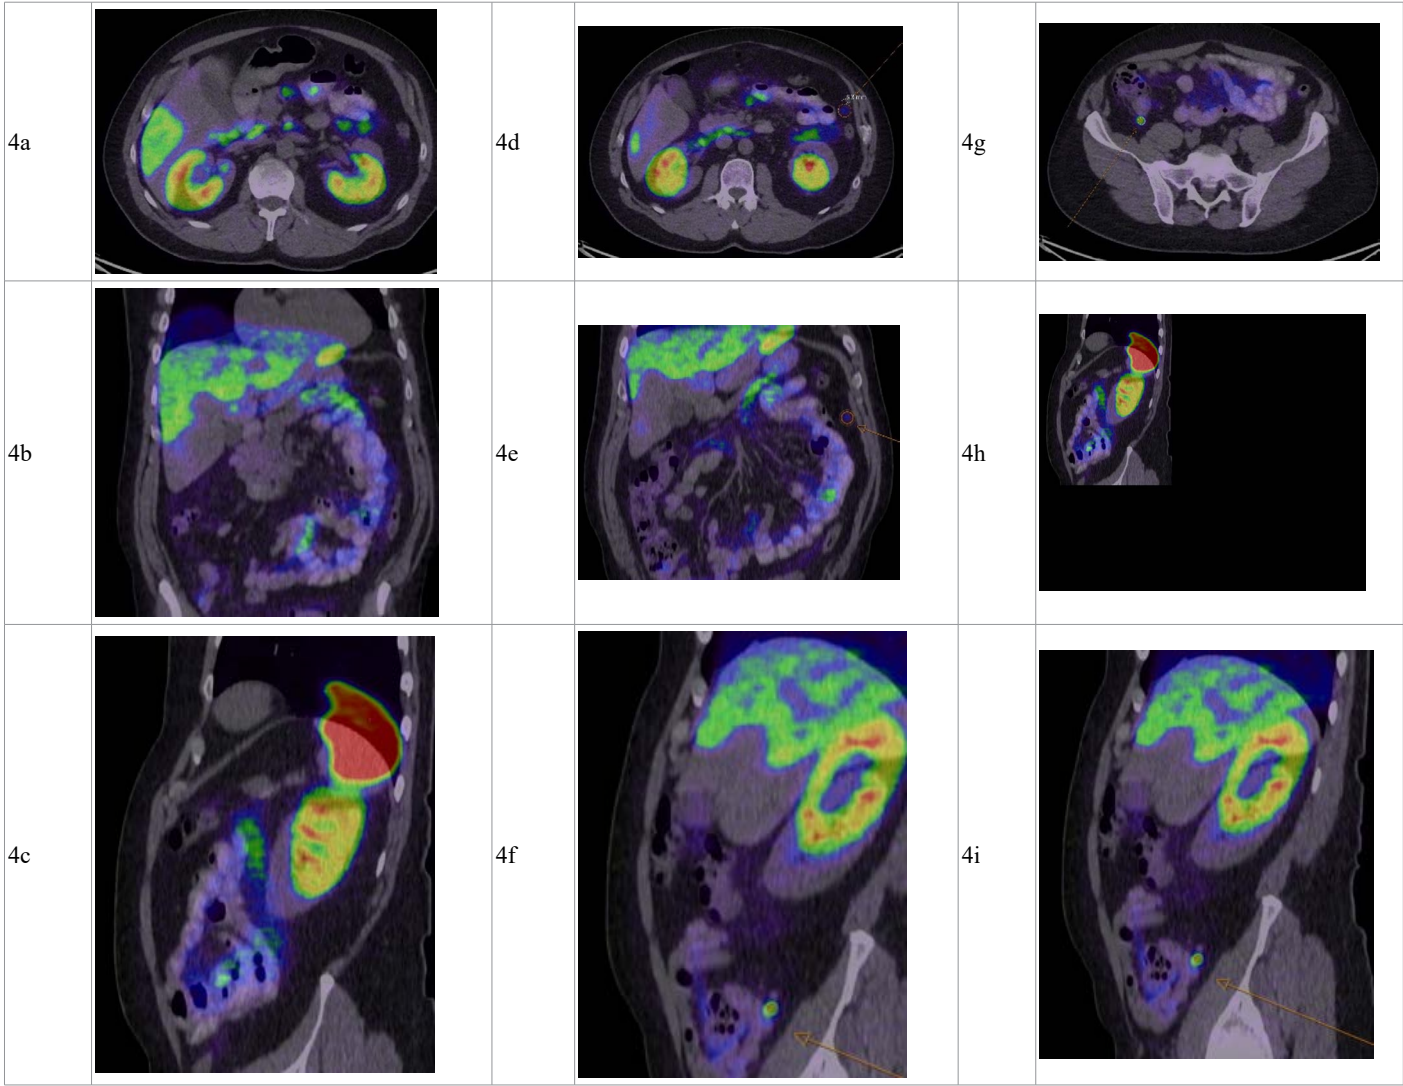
Follow-up Ga-68 DOTATATE PET/CT after resection of the pancreatic splenunculus.
